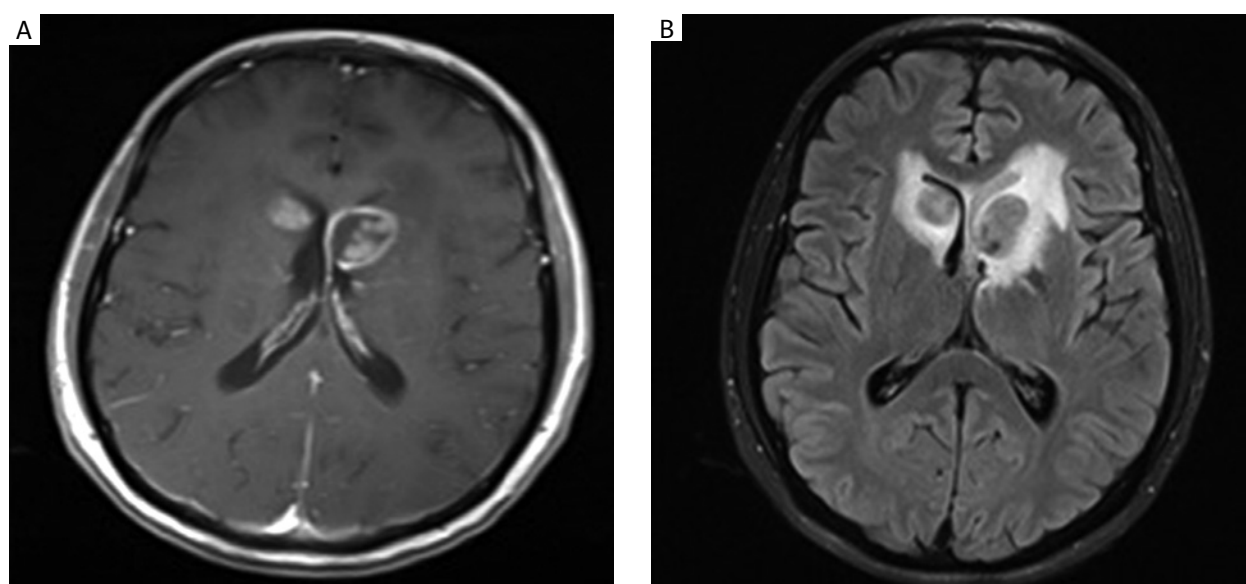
Brain MRI. Focal lesions in caudate nuclei with nodular and ring enhancement pattern. A) Axial T1 GAD and surrounding edema. B) Axial T2 FLAIR
